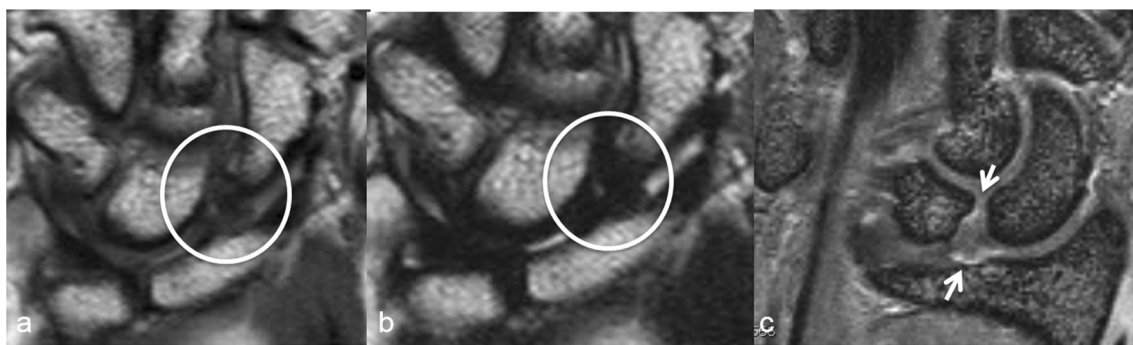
a–c Chronic sprain of the SLIL on a plain MRI compared to an indirect MRA with intravenous (iv) contrast. On the plain MRI without contrast with PD- (a) and T2-weighted (b) coronal images, the SLIL (encircled) appears amorphous and thickened by fibrous scar tissue
